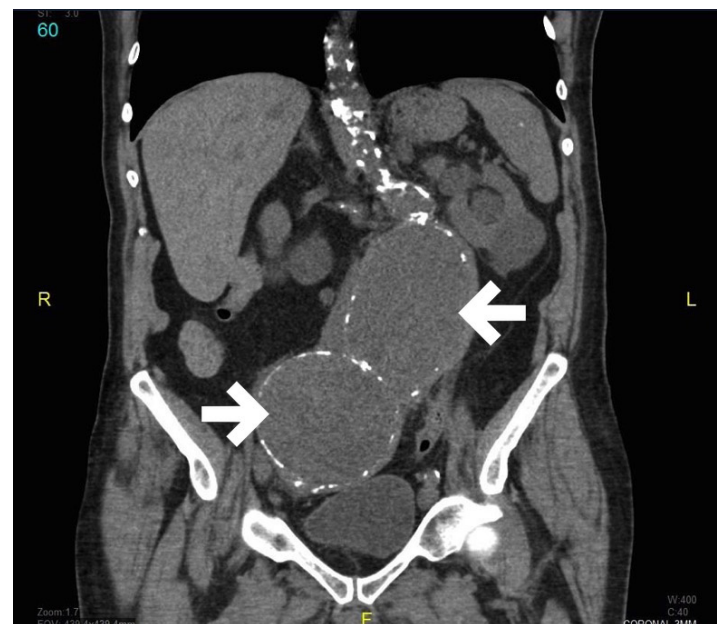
Computed tomography of the abdomen and pelvis in coronal view demonstrates a 9 x 9 cm aortic aneurysm (large arrow) and a 10 x 9 cm right common iliac aneurysm (small arrow)
